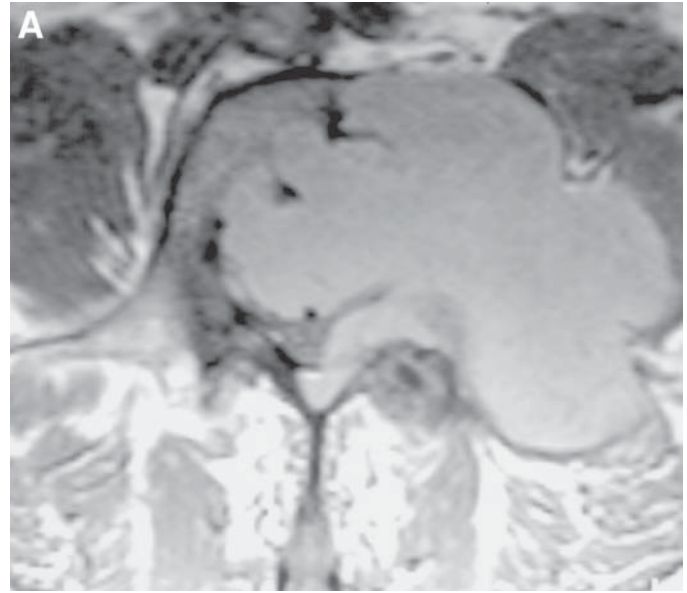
Plasmacytoma. A large enhancing lobulated soft tissue mass is identified in a lumbar vertebra extending to the paraspinal soft tissues and spinal canal on these axial (A) and sagittal (B) postcontrast T1-weighted images. The solitary form of multiple myeloma was pathologically proven.
